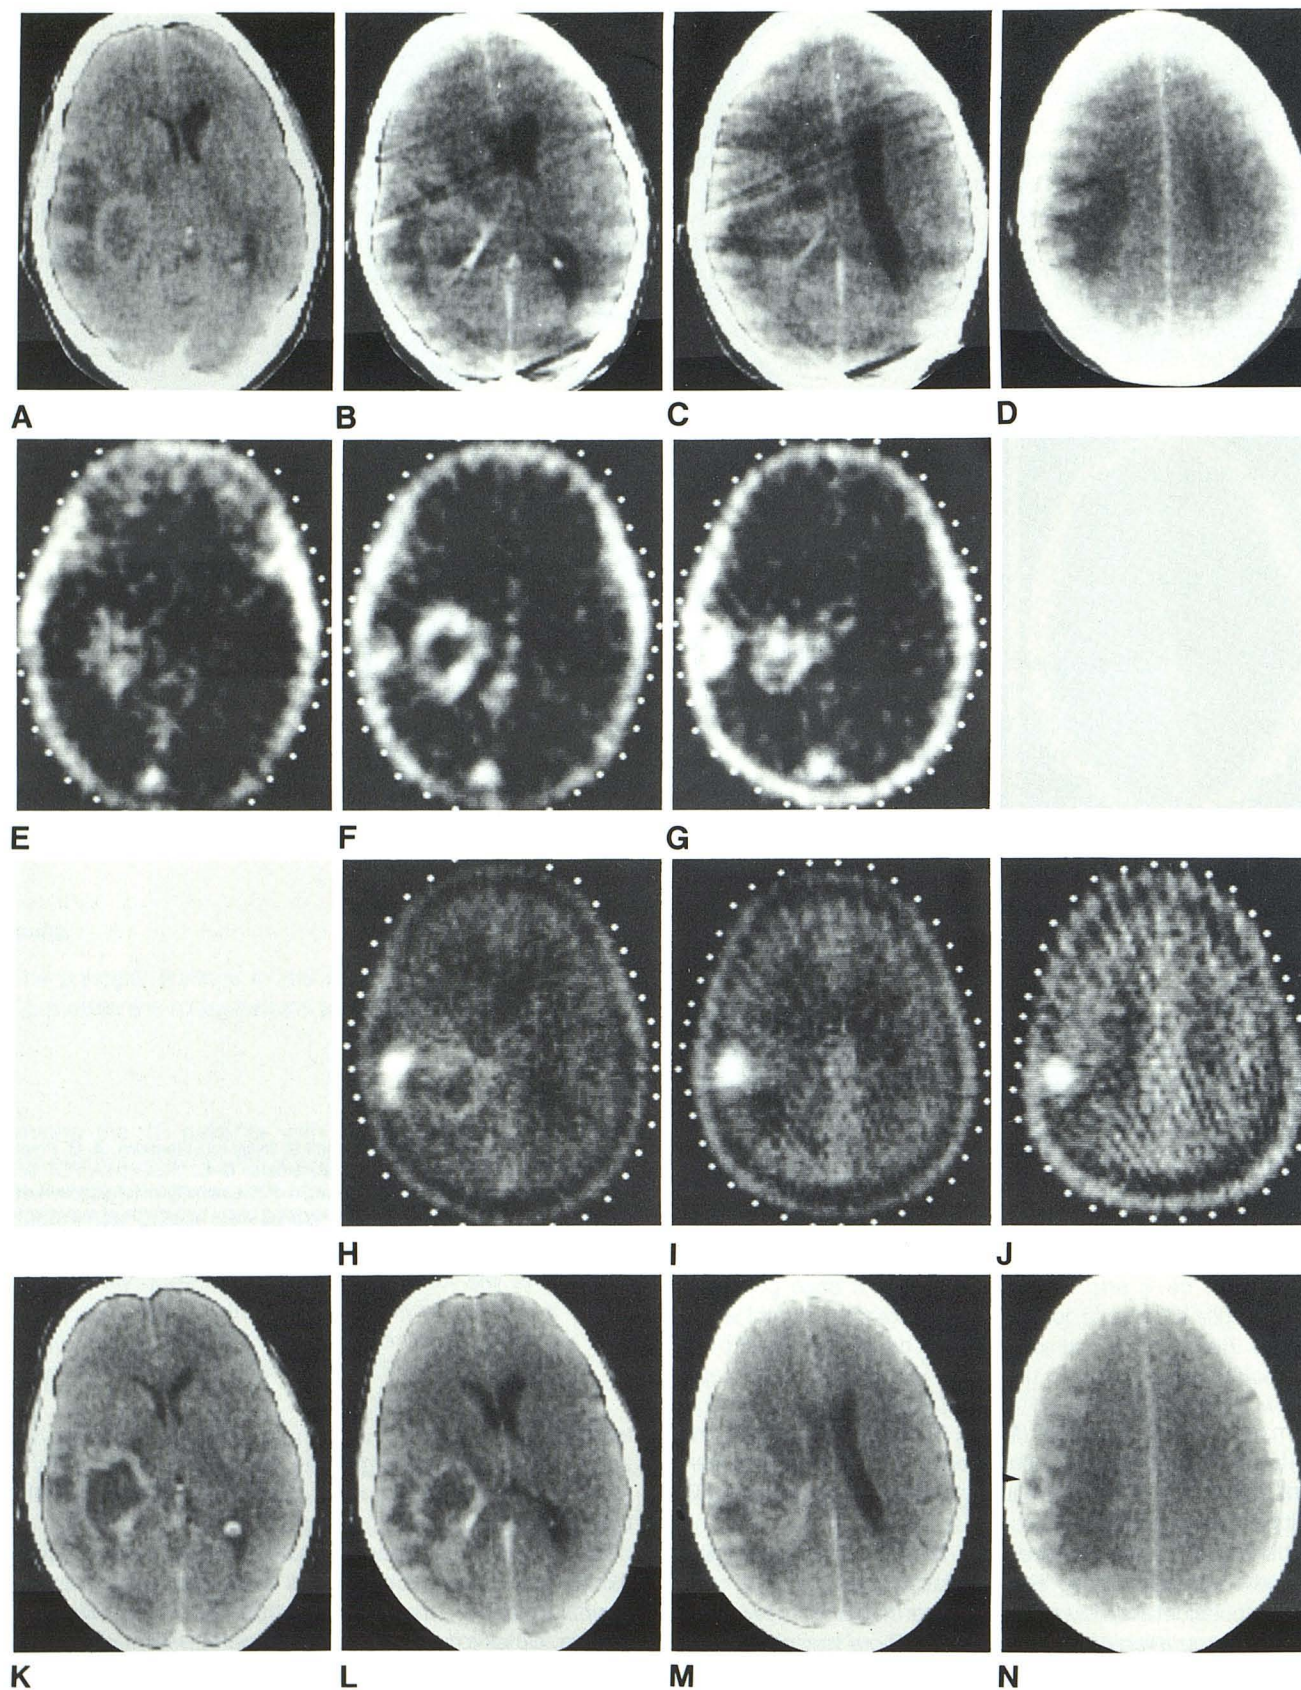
Case 10. Probable high-grade glioma adjacent to posterior part of sylvian fissure. A–D, Initial enhanced CT scans. Initial ^{68}Ga -EDTA (E–G) and ^{11}C -L-methionine (H–J) PET scans show superficial area of high uptake lateral to and more intense than "tumor ring." K–N, Enhanced CT scans 6 months later. Ringlike lesion (arrowhead) corresponds to region lateral to tumor ring.
